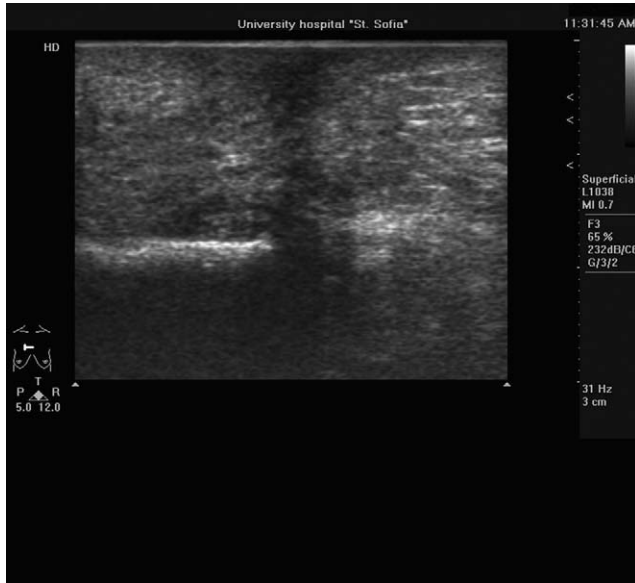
Sonography of sternum with 10 MHz linear transducer revealing loss of the “cortical reflex” at the right part of the image.
